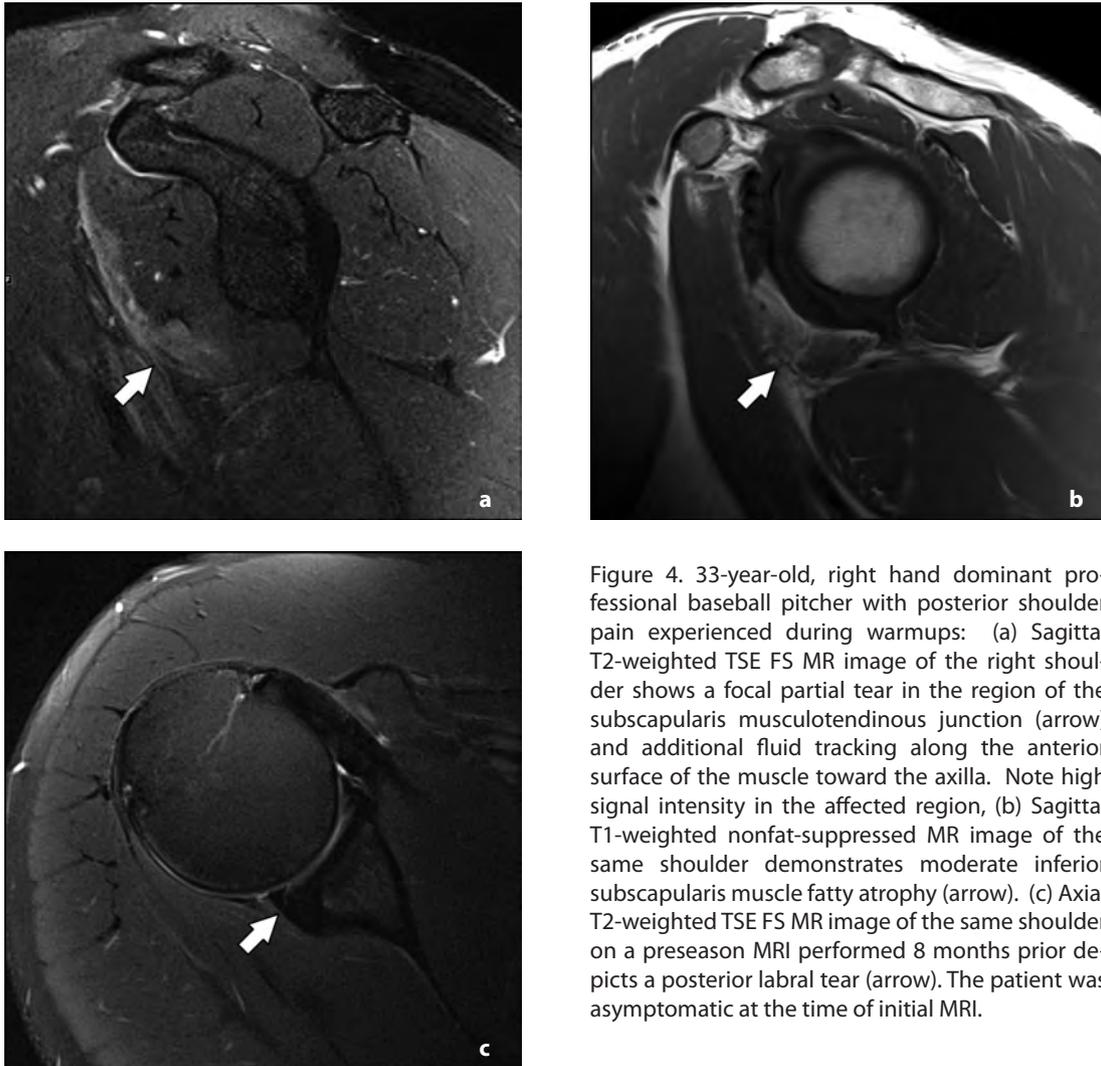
33-year-old, right hand dominant professional baseball pitcher with posterior shoulder pain experienced during warmups: (a) Sagittal T2-weighted TSE FS MR image of the right shoulder shows a focal partial tear in the region of the subscapularis musculotendinous junction (arrow) and additional fluid tracking along the anterior surface of the muscle toward the axilla. Note high signal intensity in the affected region, (b) Sagittal T1-weighted nonfat-suppressed MR image of the same shoulder demonstrates moderate inferior subscapularis muscle fatty atrophy (arrow). (c) Axial T2-weighted TSE FS MR image of the same shoulder on a preseason MRI performed 8 months prior depicts a posterior labral tear (arrow). The patient was asymptomatic at the time of initial MRI.
